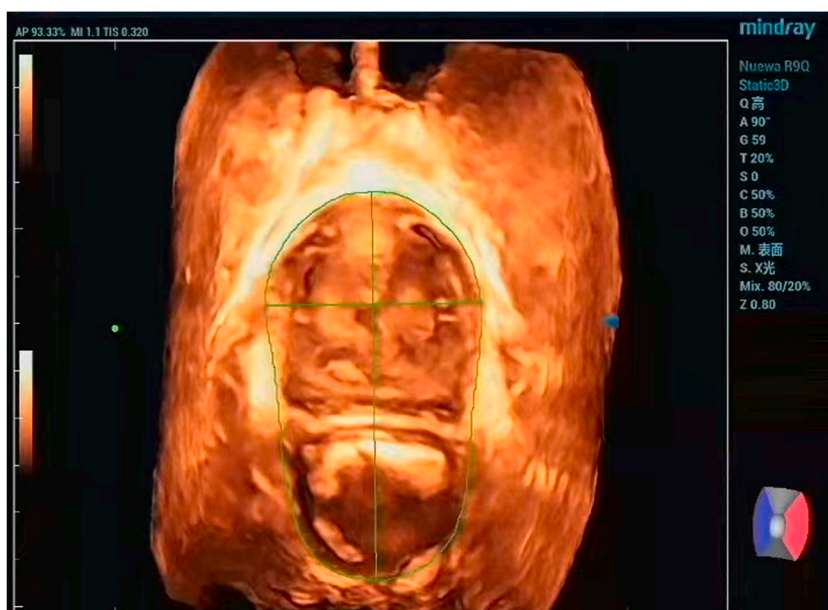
3D sonogram of the levator ani hiatus.
